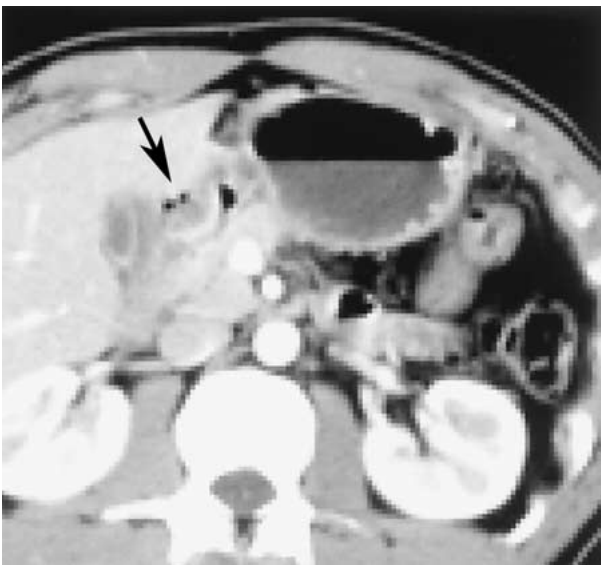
Contrast-enhanced CT image in a patient with duodenal perforation. Mural thickening of the duodenal bulb and adjacent air bubbles are visible (*arrow*).
